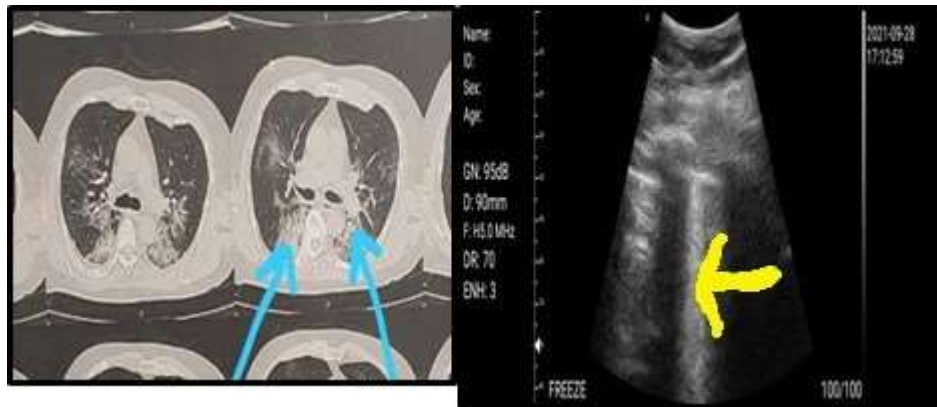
A case in this study: Computed tomography (CT) chest (left side) showing bilateral basal ground glass opacities (blue arrows) and lung ultrasound (right side) showing confluent B lines in right lower lobe (yellow arrow)
